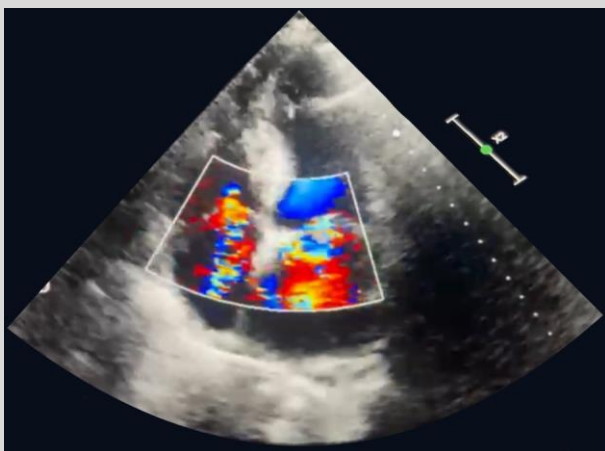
Color-Doppler showing severe eccentric mitral regurgitation.
